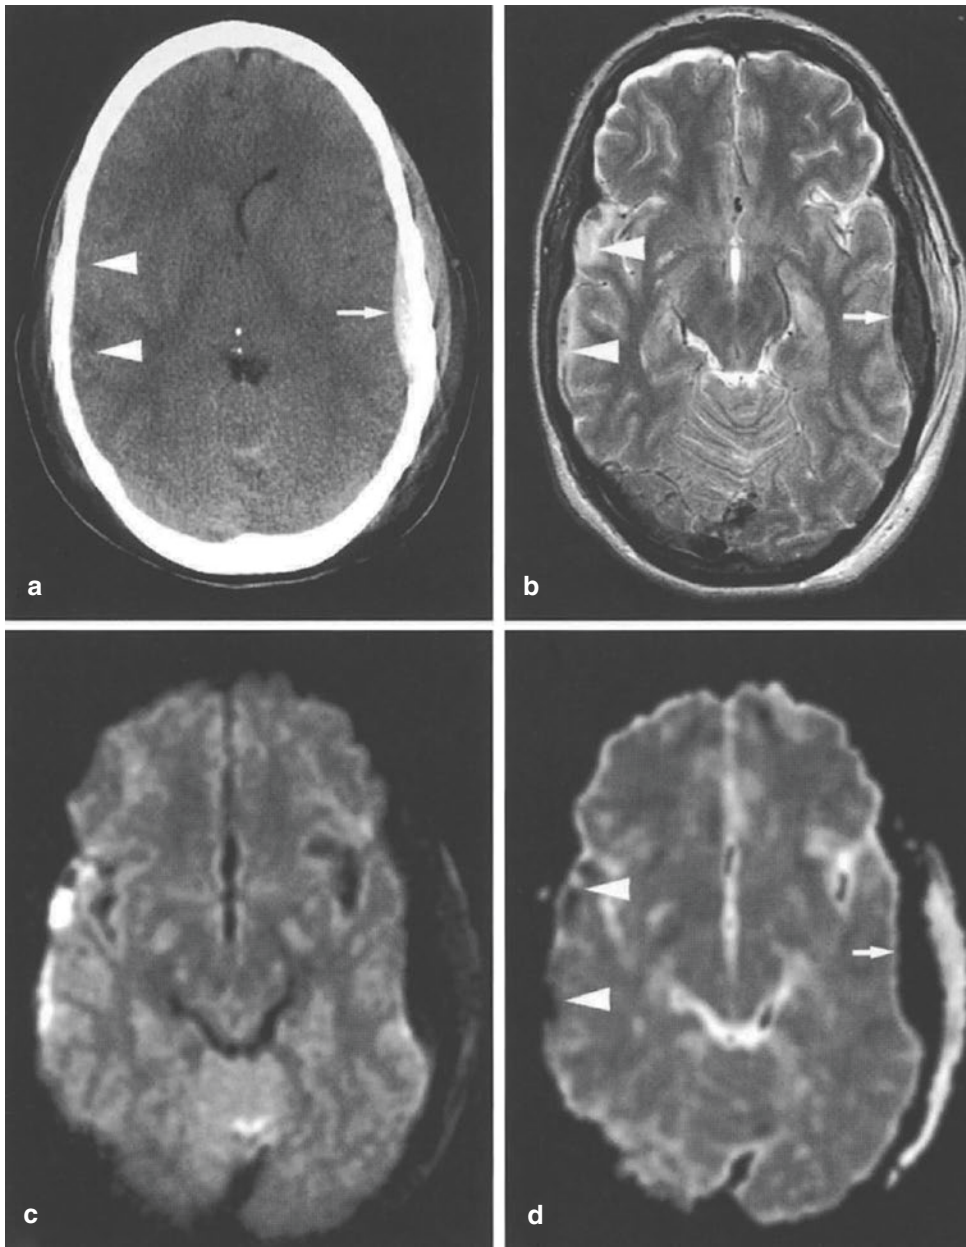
(a–d) Epidural and subdural hematoma in a 26-year-old man after a motor vehicle accident. (a) CT shows a left epidural hematoma (*arrow*) but it is difficult to depict the isodense small subdural hematoma in the right side (*arrowheads*). (b) T2-weighted image shows the left epidural hematoma (*arrow*) as a hypointense lesion and the right subdural hematoma as partially hypointense lesions (*arrowheads*). (c) DW image shows the epidural
